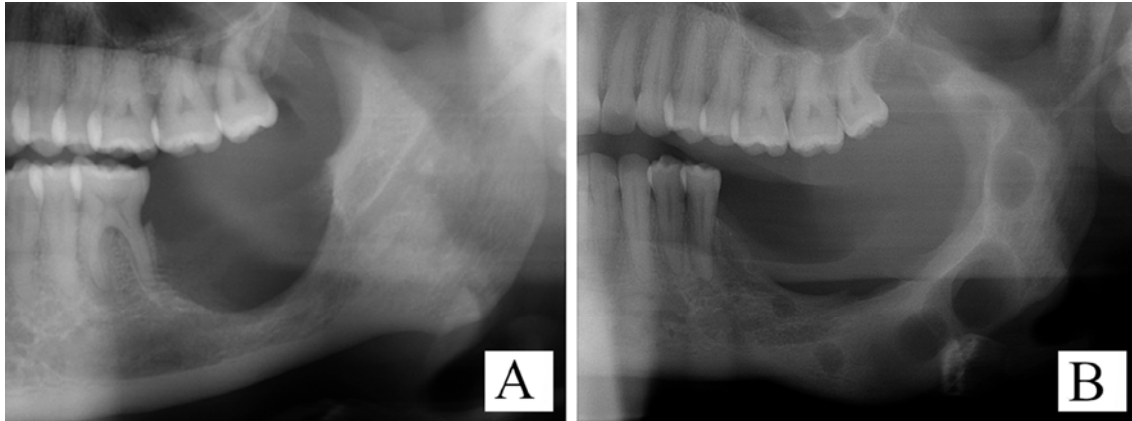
Recurrent GOC. A. Post-operative panoramic radiograph following surgical enucleation. B. Recurrence after five years showing progression in size with a multilocular appearance and bony expansion.
